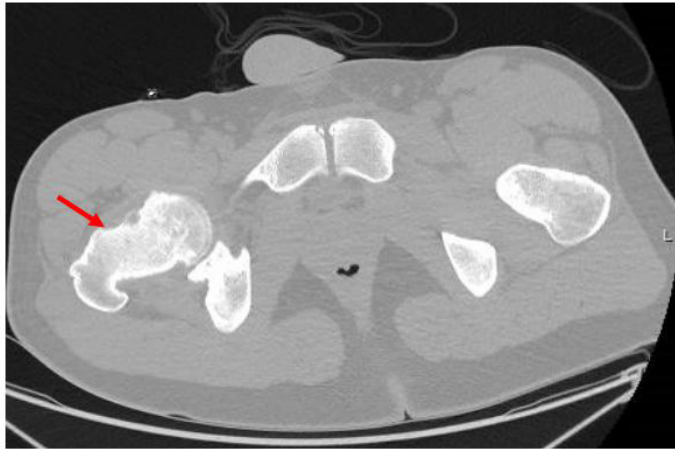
CT: “The nidus” a low-density area of 11x7 mm within a halo of bone sclerosis (arrow).
